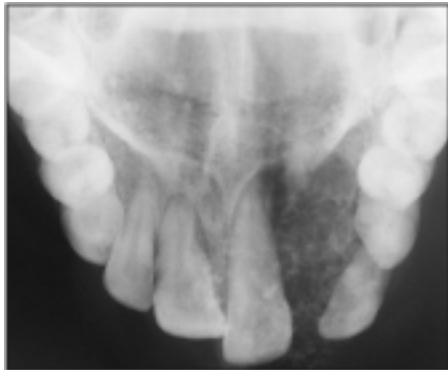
Occlusal radiograph showing the extent of the lesion (approx 4 X 4 cm) that contained small foci of calcification extending from the 11 to 22.
